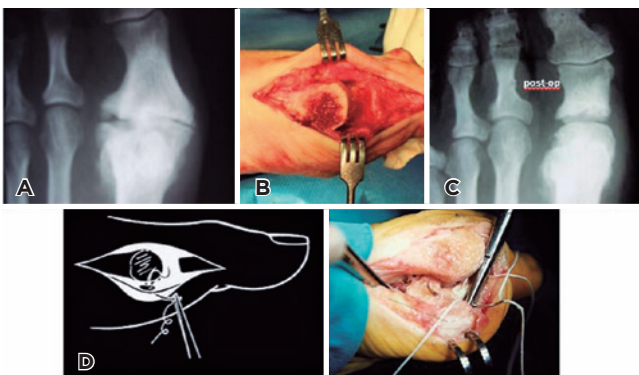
Keller technique. A) Preoperative radiograph; B) Surgical photograph of resection; C) Postoperative radiograph; D) Anchor of the flexor hallucis longus to the plantar plate, maintaining Hallux flexor strength.
